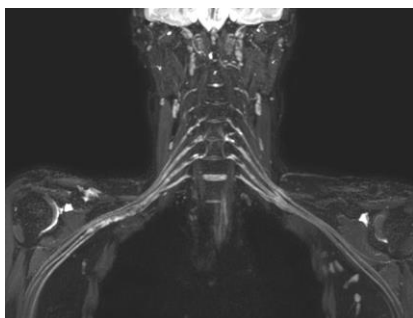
MRI showed diffuse increased signal intensity, thickening and enhancement of the right brachial plexus medial cord and median and ulnar peripheral branches
